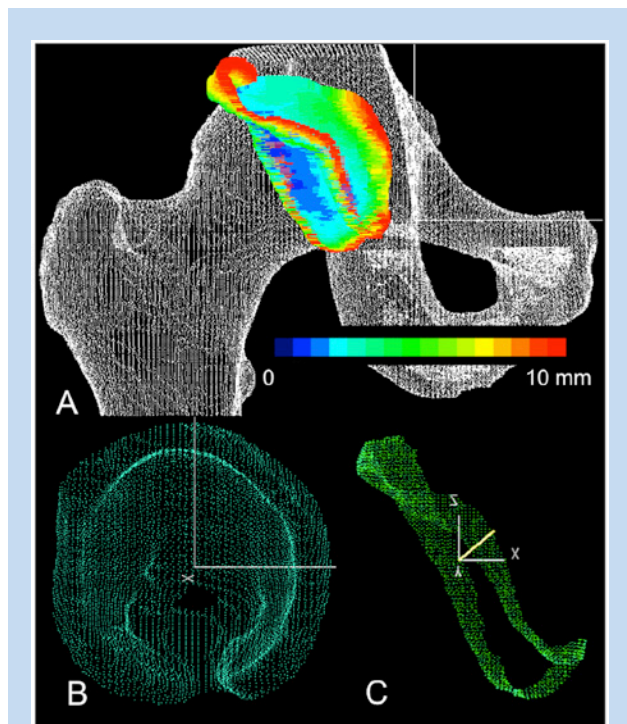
Point cloud model of the acetabulum devised from 3-dimensional computed tomography scan. (A) Joint space width represented on complete hip joint. (B) View of the modeled acetabulum surface. (C) View of the modeled acetabulum rim.
